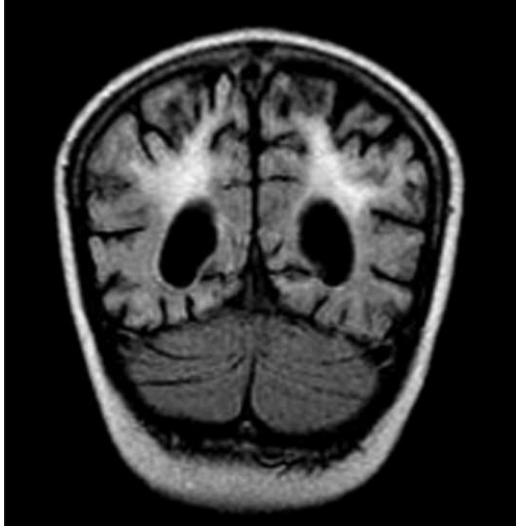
Magnetic resonance image of the brain of patient 1 at 4 years of age. Coronal FLAIR of the occipital region showing atrophy of both occipital lobes and high signal intensity in the white matter.
